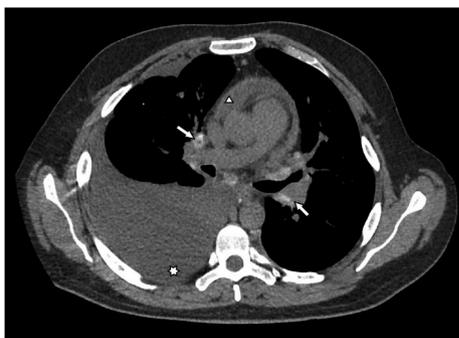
Axial image of CT chest demonstrating calcified hilar lymphadenopathy (arrows), moderate to large pericardial effusion (triangle), and moderate to large right pleural effusion (star).
